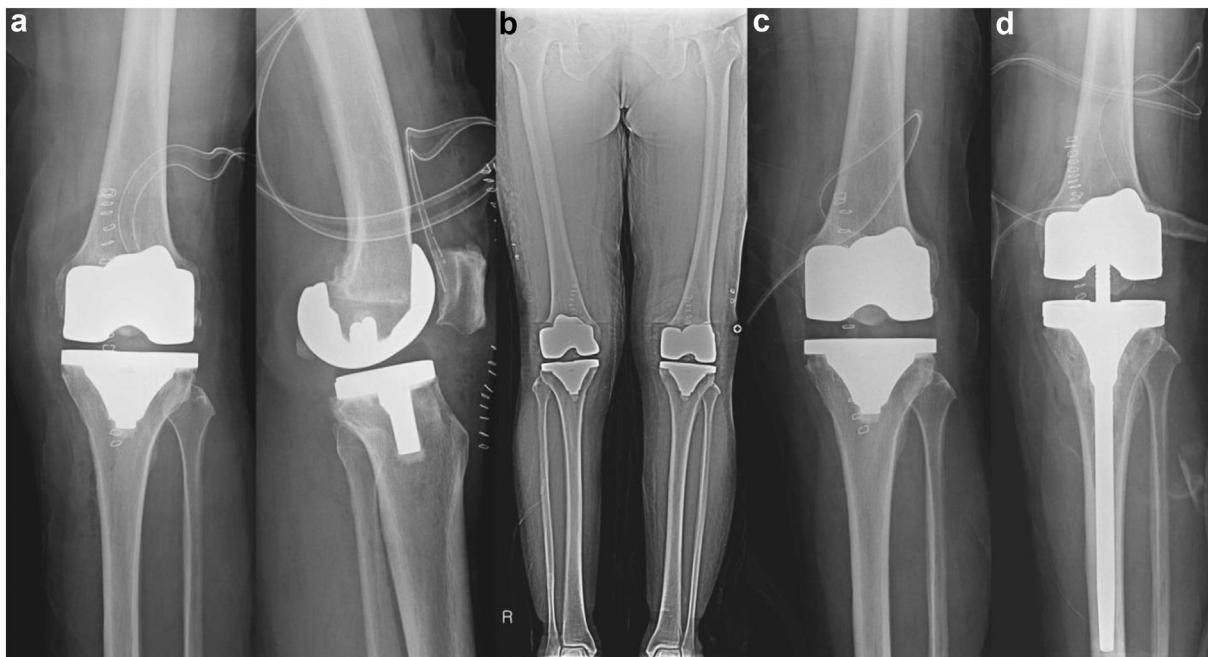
(a) Patient 4. A 63-year-old female underwent left TKA with a 10-mm tibial insert. A lateral radiograph shows a femoral component flexion angle of 4.0° and a posterior tibial slope of 1.8°. (b) A postoperative standing AP radiograph shows an HKA angle of 1.8°. (c) She underwent isolated tibial insert exchange with a 15-mm tibial insert following a tibial post fracture. (d) Postoperative radiograph shows tibial revision surgery with a TS tibial insert after a tibial post refracture.
